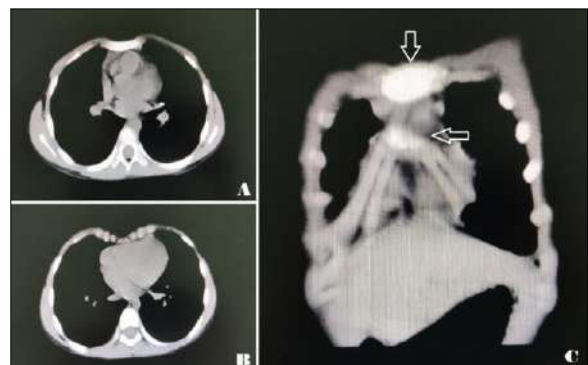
CT scan image of the thorax. A, axial plane of the upper part of the thorax; B, axial plane of the lower part of the thorax; C, coronal plane of the thorax.
